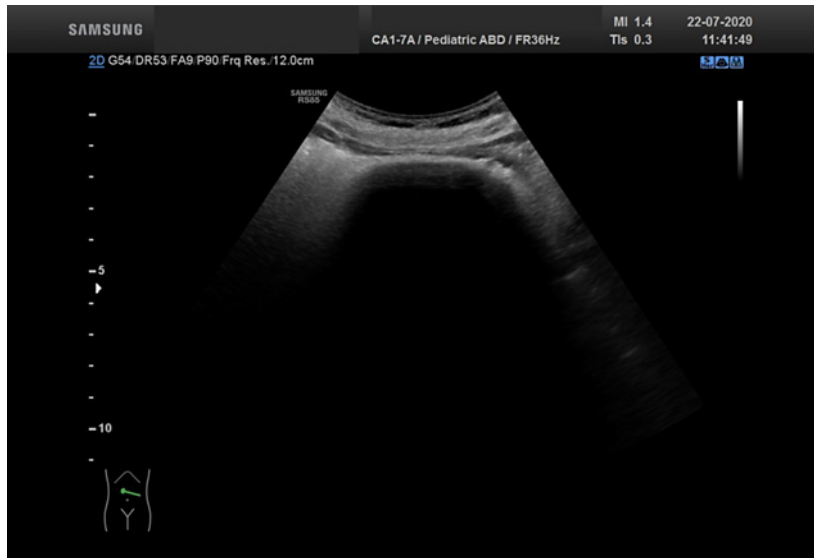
Abdominal ultrasound with acoustic shadowing.
